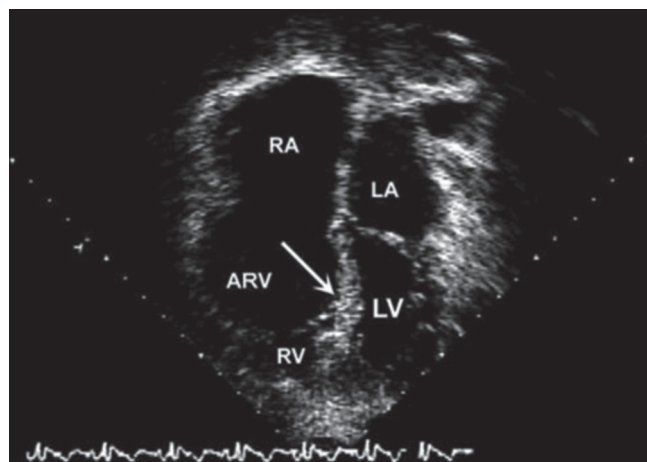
■ Example of an echocardiogram (four-chamber view, apex down) of a patient with severe Ebstein malformation showing a grossly displaced septal leaflet (arrow). The anterior leaflet is severely tethered (“failure of delamination”) and nearly immobile. The atrialized right ventricle (ARV) is large and the functional right ventricle (RV) is small. LA, Left atrium; LV, left ventricle; RA, right atrium. (From Said SM, Dearani JA: Ebstein anomaly, congenital tricuspid valve regurgitation and dysplasia. In Allen HD, Driscoll DJ, Shaddy RE, Feltes TF, editors: *Moss and Adams’ heart disease in infants, children, and adolescents*, ed 8, Philadelphia, 2013, Lippincott Williams & Wilkins, Figure 39-15.)
